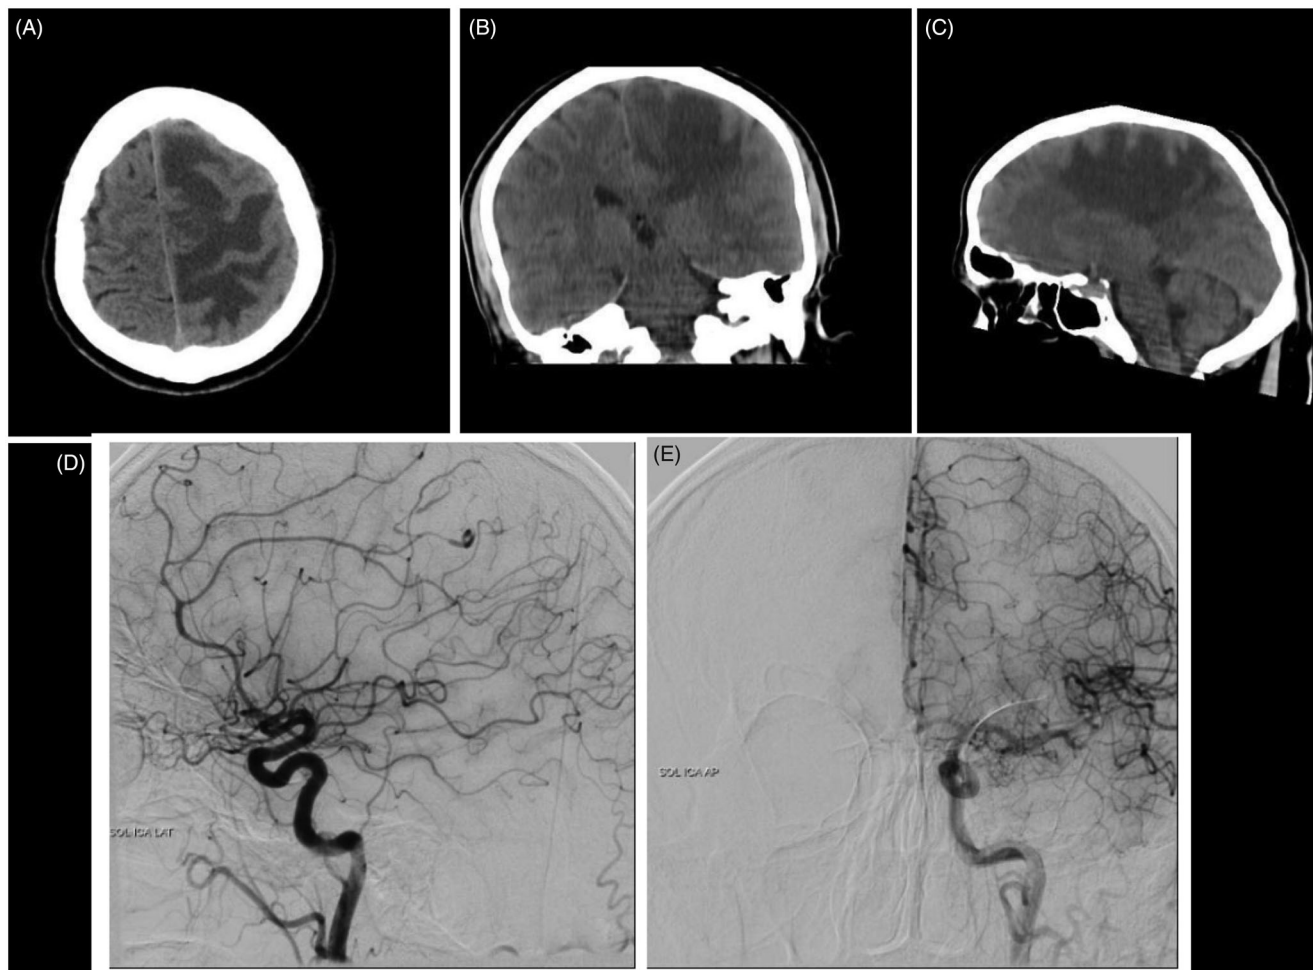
Cranial CT (A,B,C) and DSA (D,E) 12 months after radiosurgery; with significant reduction of the AVM size.
